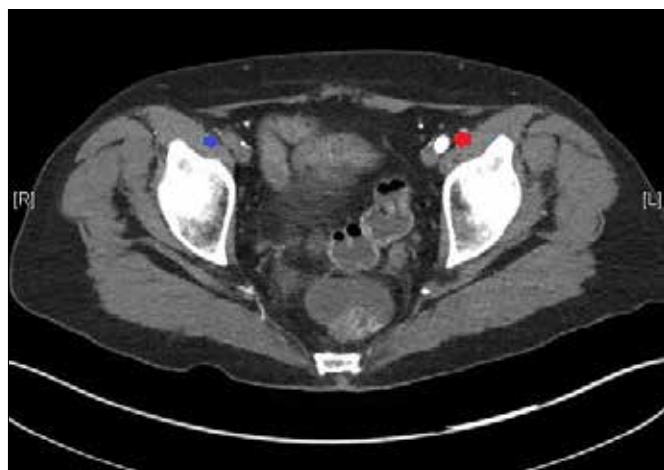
CTA confirming occlusion of right external iliac artery (blue arrow) vs. patent left external iliac artery (red arrow)
